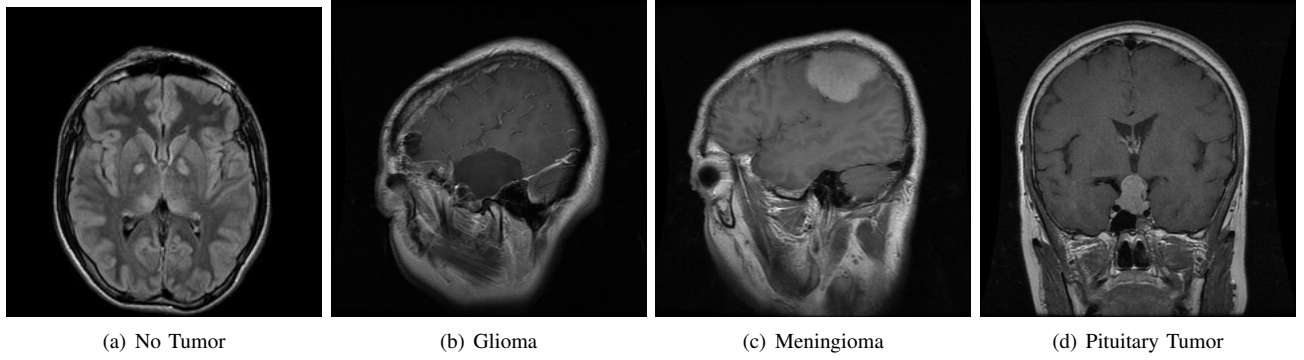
Example MRI Scans From Four Different Classes in the Dataset
